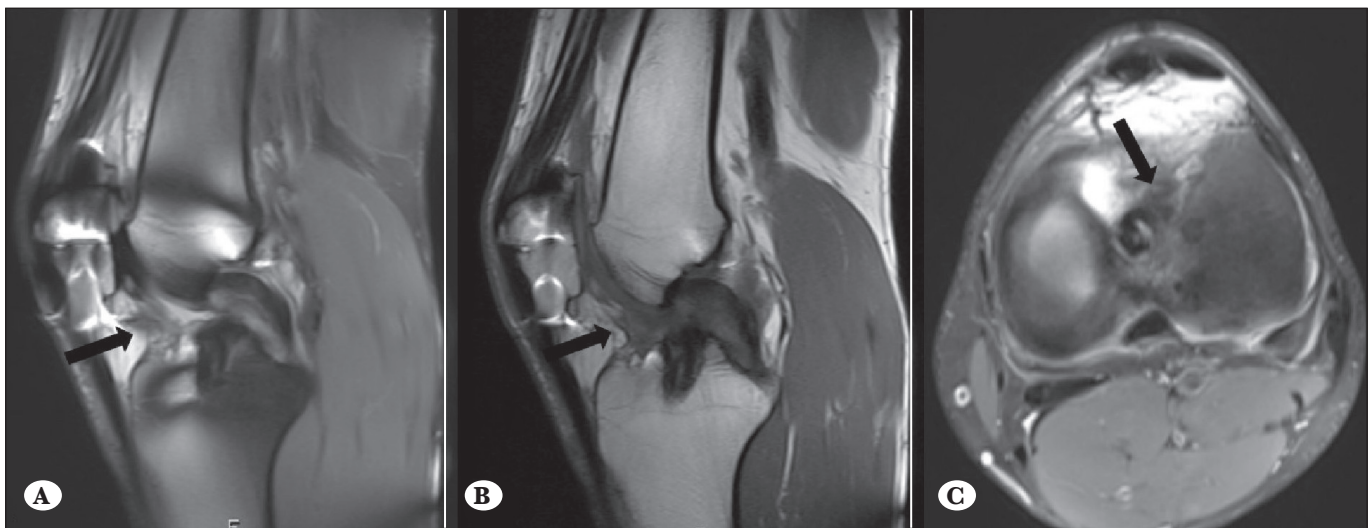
Sagittal PD-weighted fat suppressed (A), T1-weighted (B) and axial PD-weighted fat suppressed (C) MR images showing hypointense soft tissue mass (arrow) anterior of the ACL graft and intercondylar notch to the posterior to the infrapatellar fat pad.
